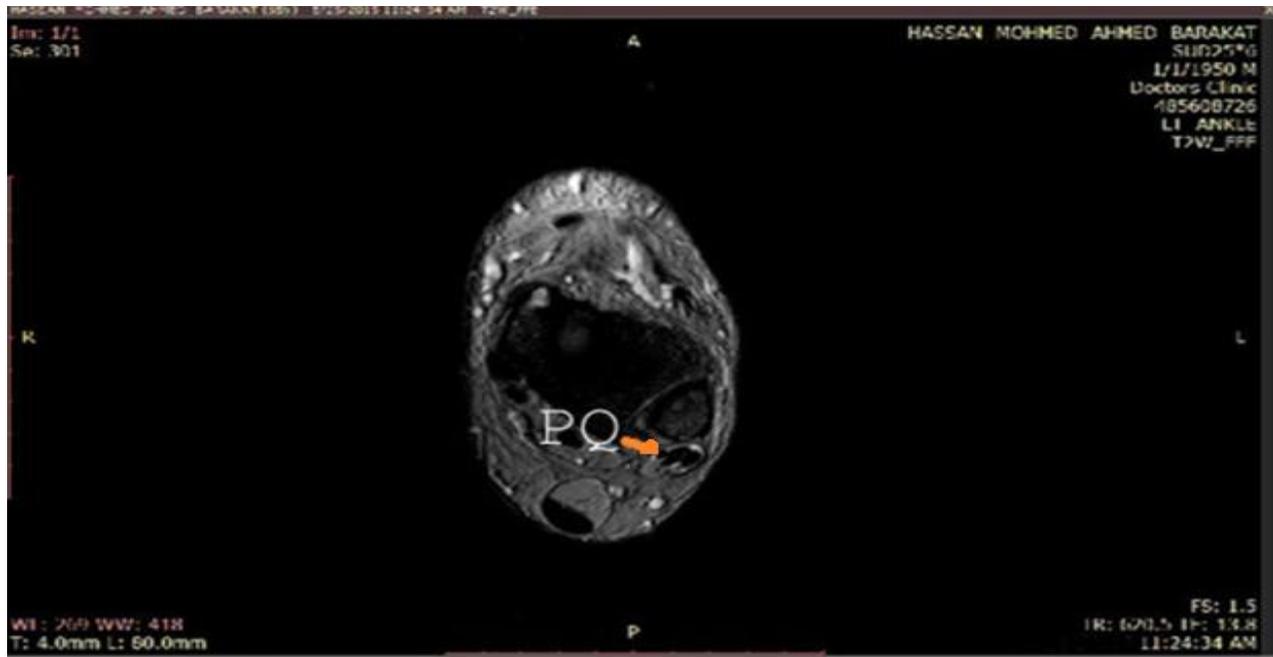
MRI T2W axial cut of left ankle of male subject shows the presence of PQ muscle (red arrow) .
